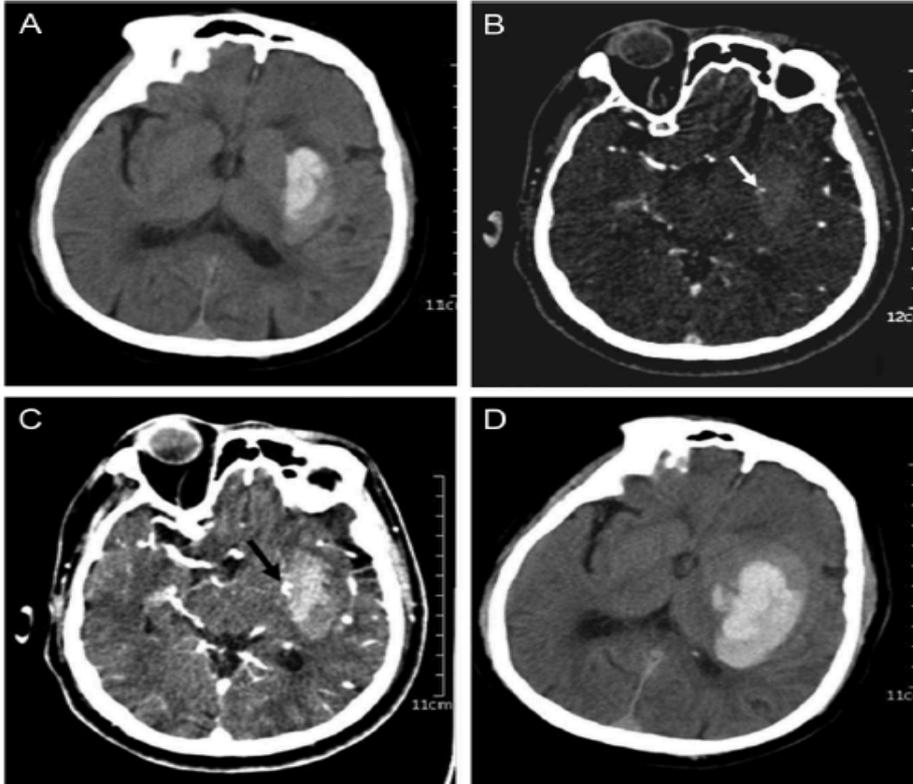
MDCTA at 2 hours after symptom onset. A, Baseline NCCT demonstrated hematoma in left basal ganglia. B–C, Contrast extravasation was shown on MDCTA source image (white arrow) and reconstructed image (black arrow). D, Follow-up NCCT at 24 hours showed hematoma expansion. MDCTA indicates multidetector CT angiography; NCCT, noncontrast CT.
